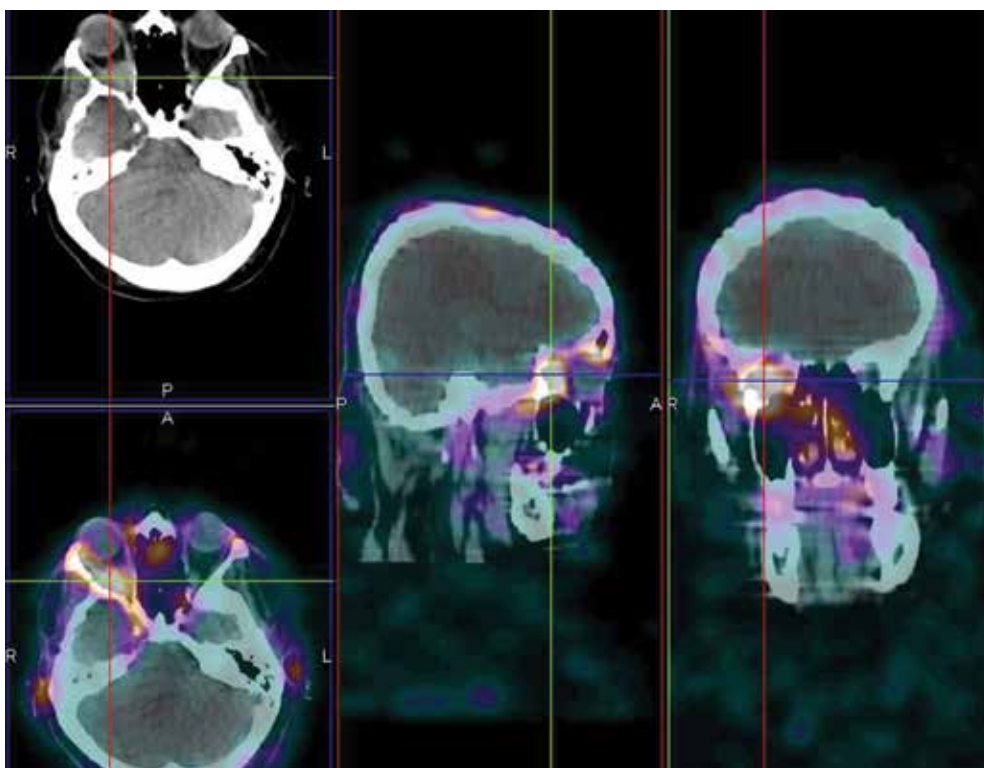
A 42-year-old female with NET G2 (Ki67 8%) of lacrimal gland (case number 6). ^{99m}Tc -EDDA/HYNIC-TOC SPECT/CT was done as preoperative staging. SPECT/CT (axial, sagittal and coronal view) showed increased radiopharmaceutical uptake in the right orbital cavity. NET G2, neuroendocrine tumor grade 2; SPECT/CT, single photon emission computed tomography/computed tomography
